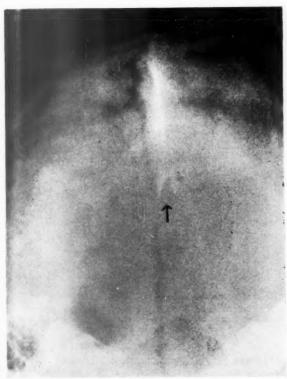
Radiograph of skull showing bony defect in occipital bone.
